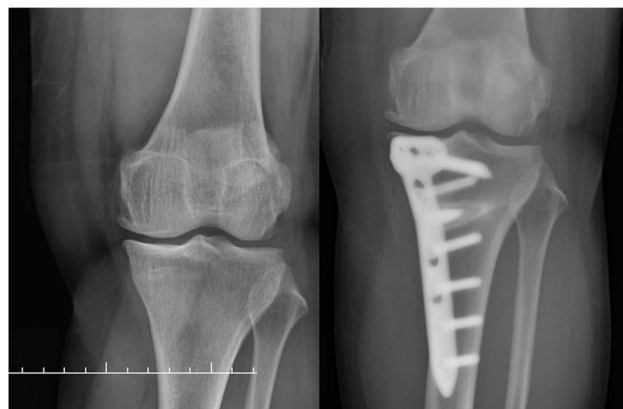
Preoperative and postoperative radiography images of a 69-year-old patient with grade II gonarthrosis who underwent medial opening wedge high tibial osteotomy
